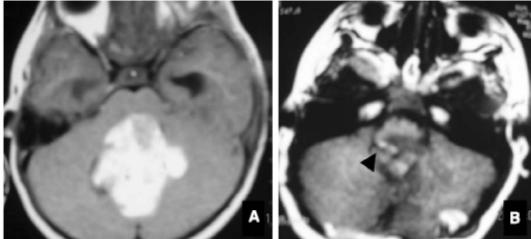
(A, B). In (A) axial T1-weighted MRI with Gd-DTPA showing fourth ventricular tumour in a 6 years old child with homogenous contrast enhancement. In (B) postoperative axial, T1-weighted MRI with Gd-DTPA showing subtotal tumour removal. Residual tumour attached to the inferior cerebellar peduncle is indicated by black arrowhead. It was an ependymoma.
